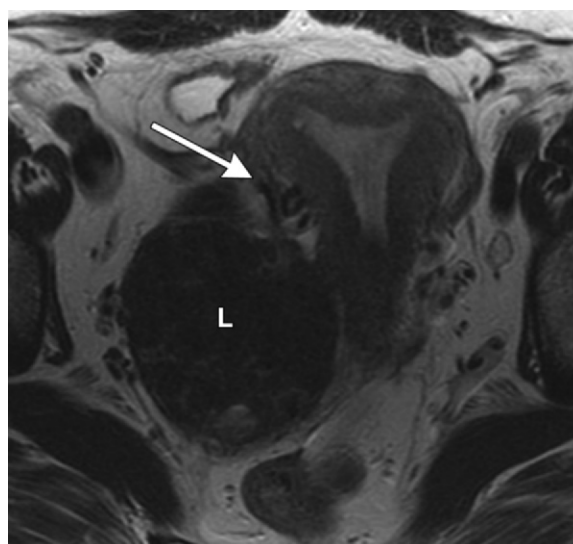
Differentiation of a leiomyoma from an adnexal mass. Axial T2-weighted image shows a broad-based subserosal leiomyoma (*L*) with associated bridging vessels (arrow). The presence of bridging vessels allows the diagnosis of leiomyoma to be made, thereby allowing exclusion of an adnexal mass. (Courtesy of Evis Sala, MD, PhD, Memorial Sloan-Kettering Cancer Center, New York, NY.)
